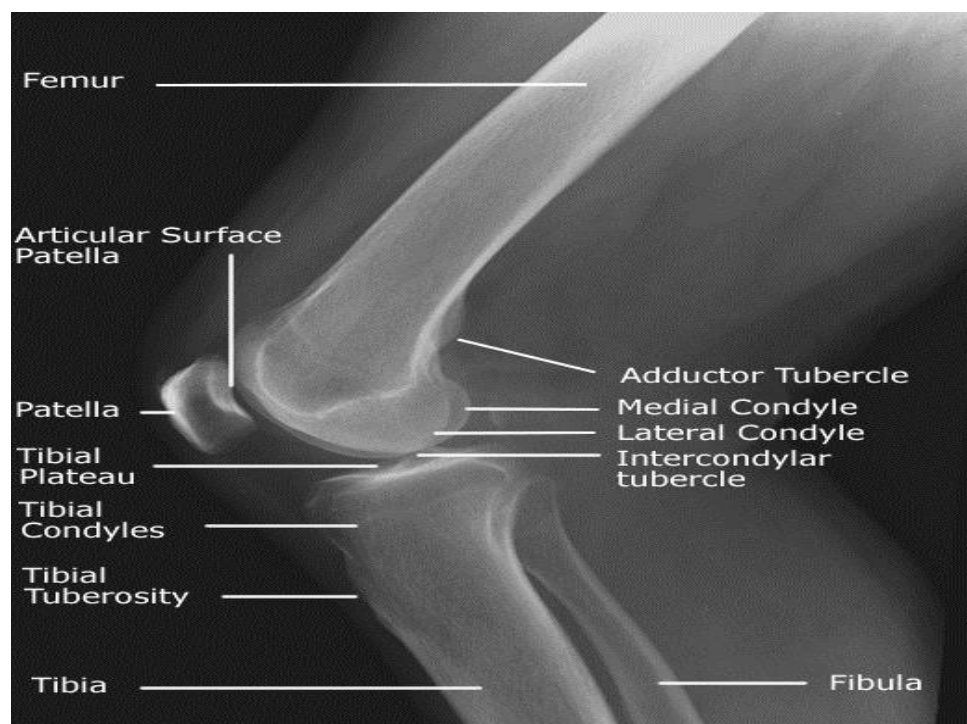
Shows lateral knee X-Ray
